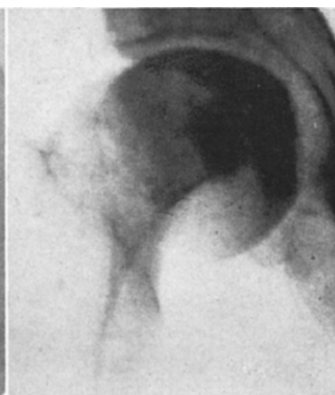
Case xvi. Roentgenogram eight years previous to Figure 84, January 26, 1926. Original condition: slipping epiphysis.
